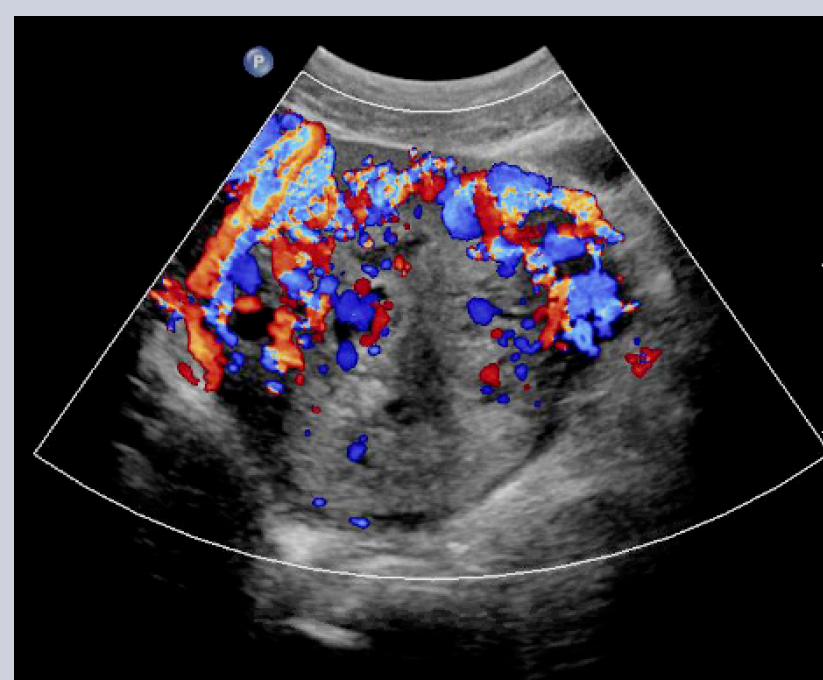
Ultrasound at presentation shows enlarged uterus with dilated varicose vessels throughout the myometrium and surrounding the endometrium with exuberant color Doppler flow
